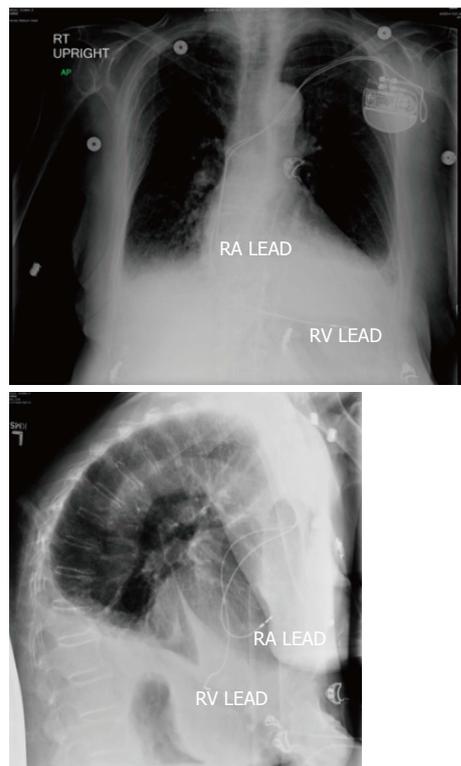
Chest X-ray showing proper placement of right ventricular and right atrial leads. RA: Right atrium; RV: Right ventricle.
